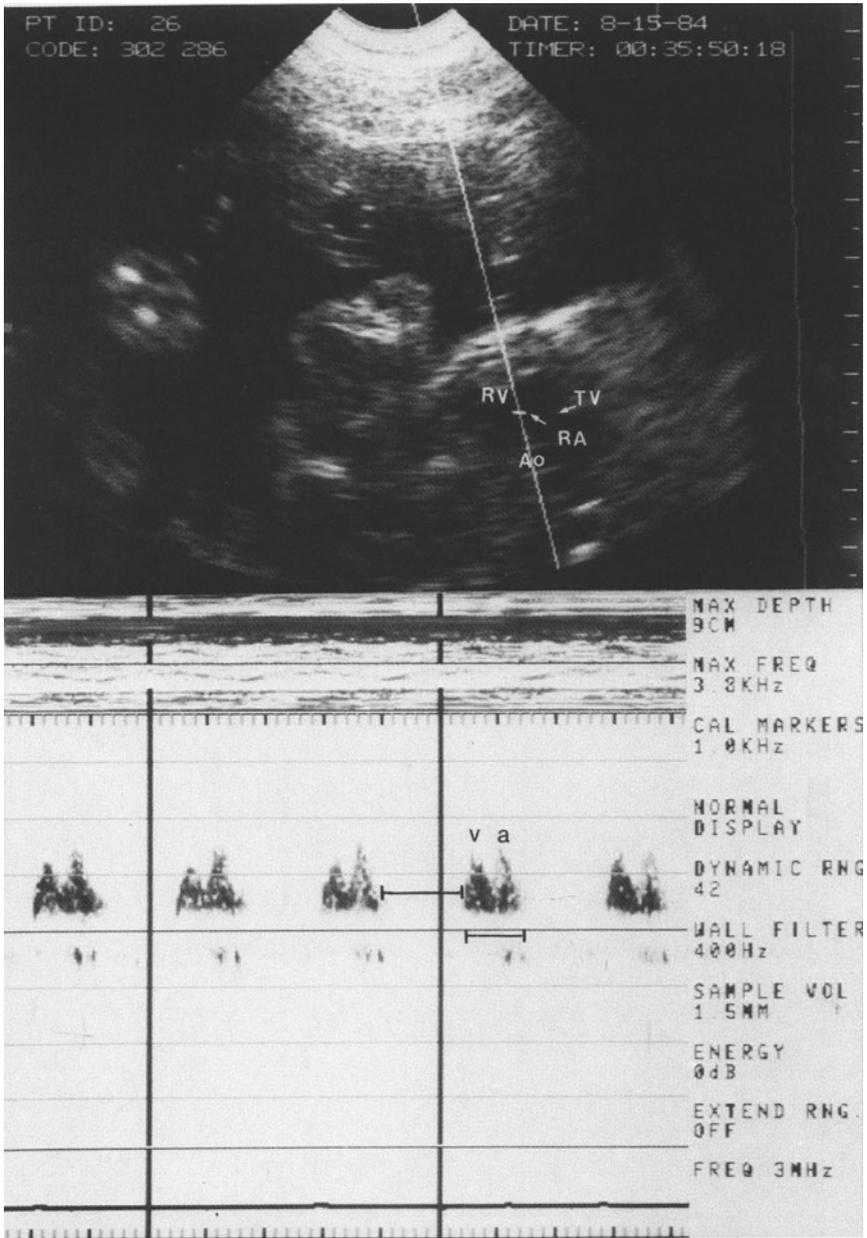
The top frame from a 26-week-old fetus shows the sample volume (bar) in the tricuspid funnel (*TV*) between right atrium (*RA*) and right ventricle (*RV*). The aorta (*Ao*) lies posteriorly. The arrow indicates the vector of diastolic blood flow, the resulting Doppler spectral output with venous flow wave (*v*), and that resulting from atrial contraction (*a*). The A wave has a slightly greater frequency shift than the V wave. The bars indicate diastolic periods with the V and A waves and systolic period where no flow is recorded.
